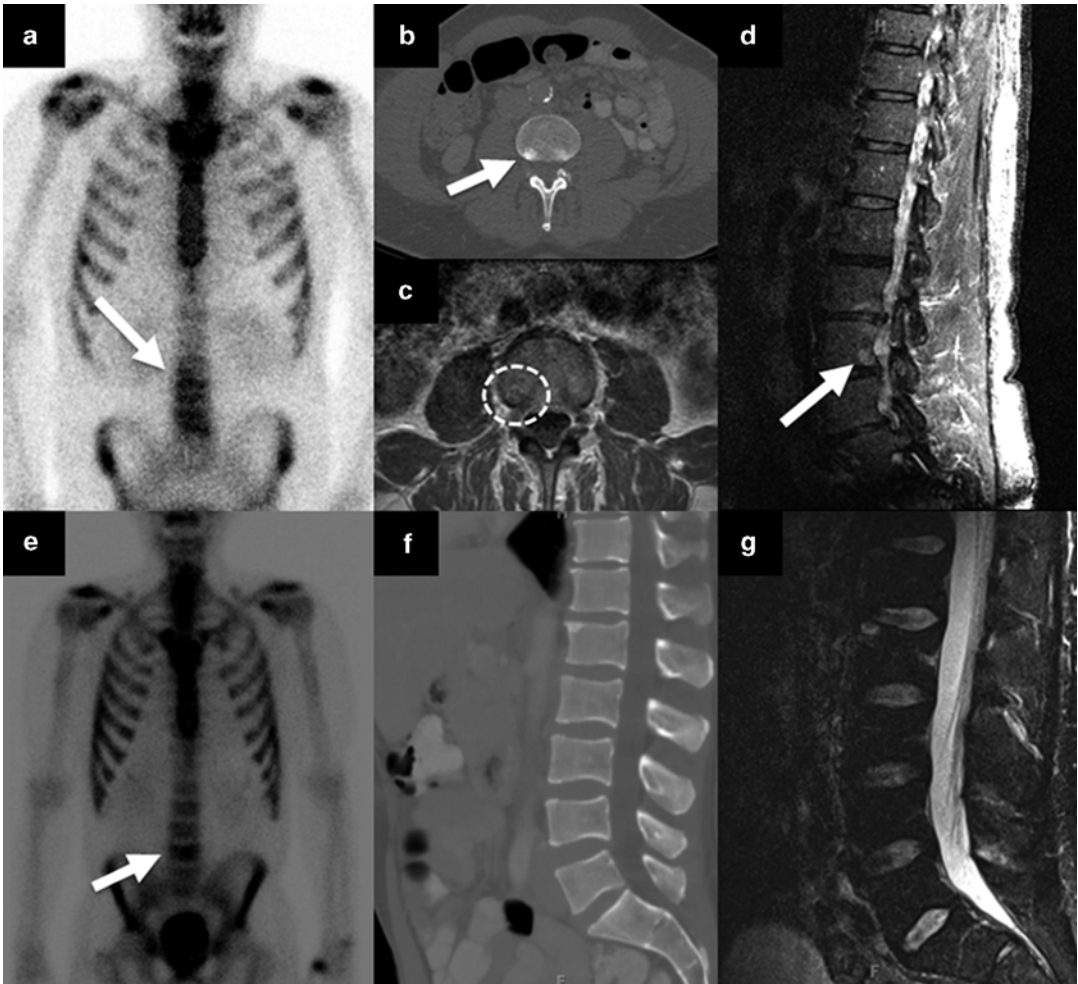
Appearance of a bone metastasis and benign lesion on cross-sectional images and BS. A 67-year-old man with biopsy Gleason score 5+4, BS showed mild uptake on the right at the L3 vertebral body level (a), CT showed 1 cm rounded sclerotic focus on the right side of the L3 vertebral body (b), and confirmatory findings on MRI identified metastasis with focal signal loss combined with peripheral
